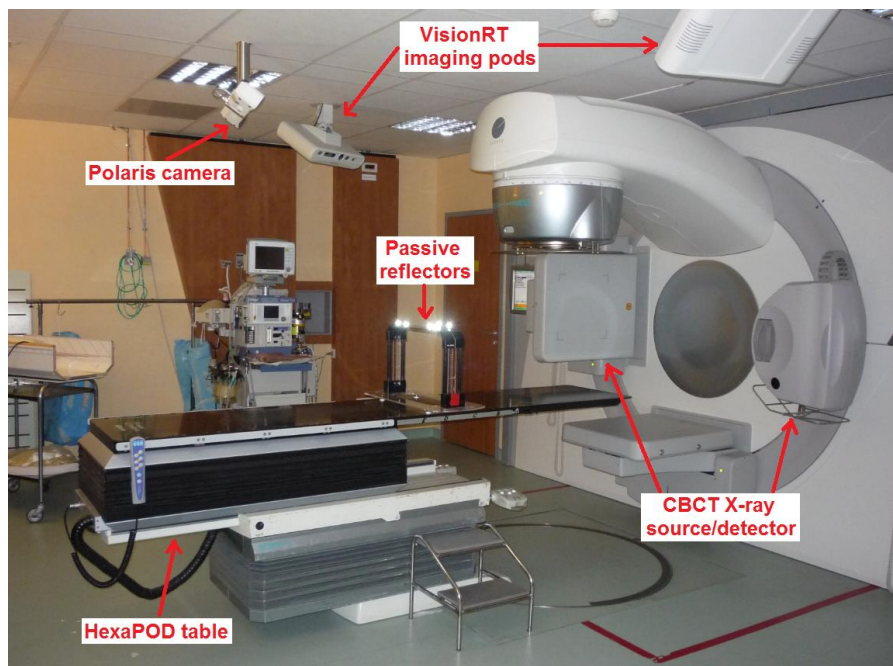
Photo of the treatment room at the Centre Léon Bérard where the Elekta SynergyS system is installed. The couple of X-ray source and panel detector for cone-beam CT imaging and the VisionRT pods for surface scanning are depicted in the figure. The HexaPOD table is also highlighted, including the Polaris camera and the passive reflective markers attached to the top of the treatment couch.
